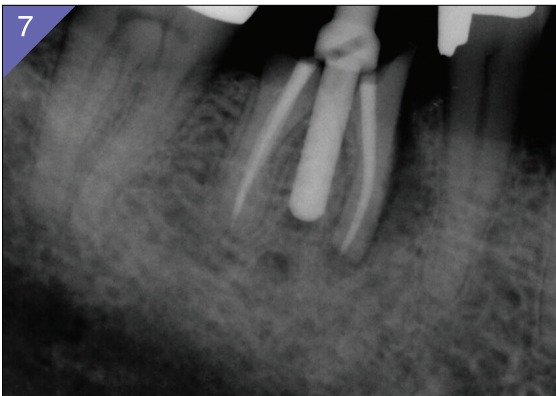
Periapical radiograph of the angulation pin in place.
